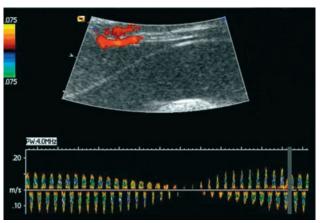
The characteristic interference pattern (a) seen with pulsed-wave Doppler insonation of an arterioarterial anastomosis. Superimposition of two umbilical artery waveforms results in the three characteristics: a bidirectional waveform, a speckled appearance when viewed by spectral Doppler and a periodicity dependent upon the difference in twin heart rates. Reproduced with permission from *Human Reproduction*. The periodicity of the Doppler waveform is highlighted by using a slower sweep (b) (25 mm/s vs. 50 mm/s)
